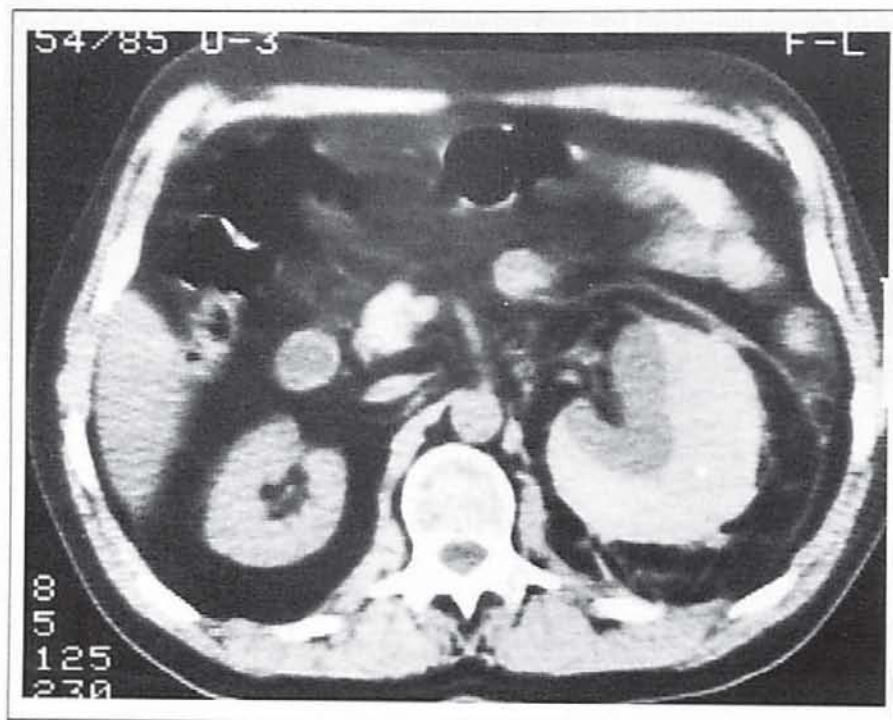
Large perirenal hematoma after ESWL showed in CT scan. Conservative management
